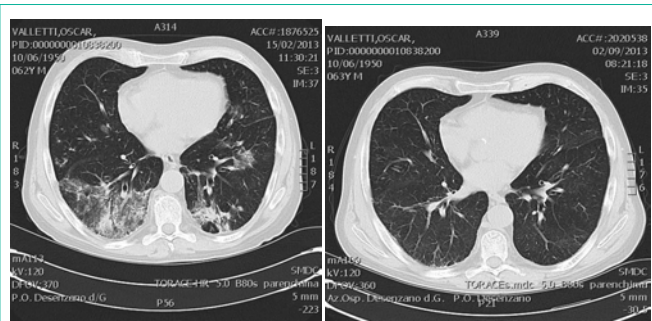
HRCT at the beginning of the treatment with TCZ and after 10 months.
